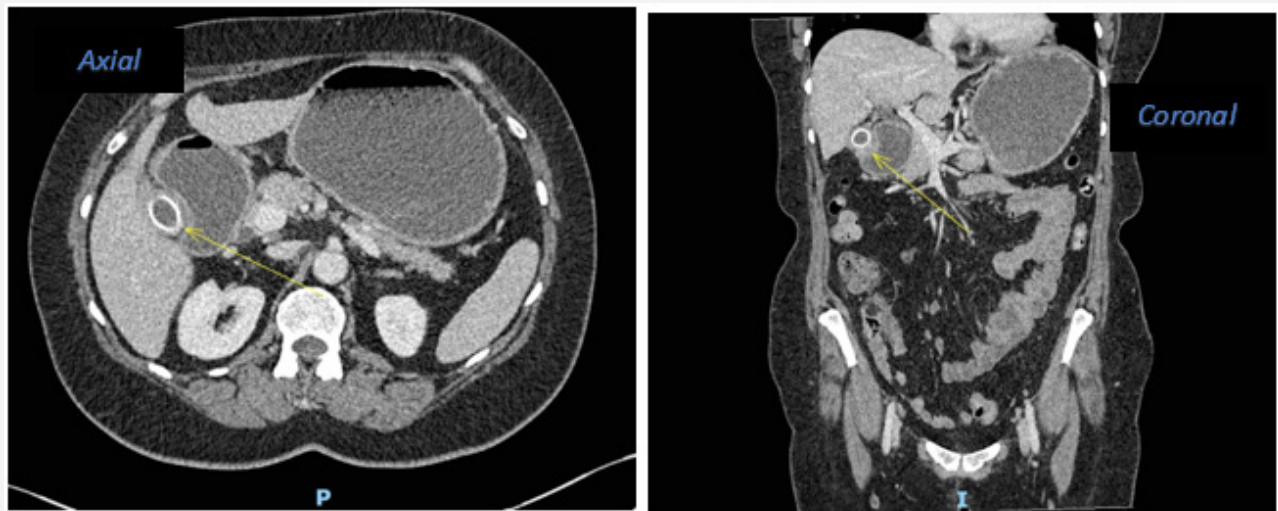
Axial and coronal views of the CT abdomen and pelvis with contrast. A yellow arrow shows a radiolucent stone within the gallbladder remnant which causes extrinsic compression of duodenum with associated duodenal and stomach dilatation.
